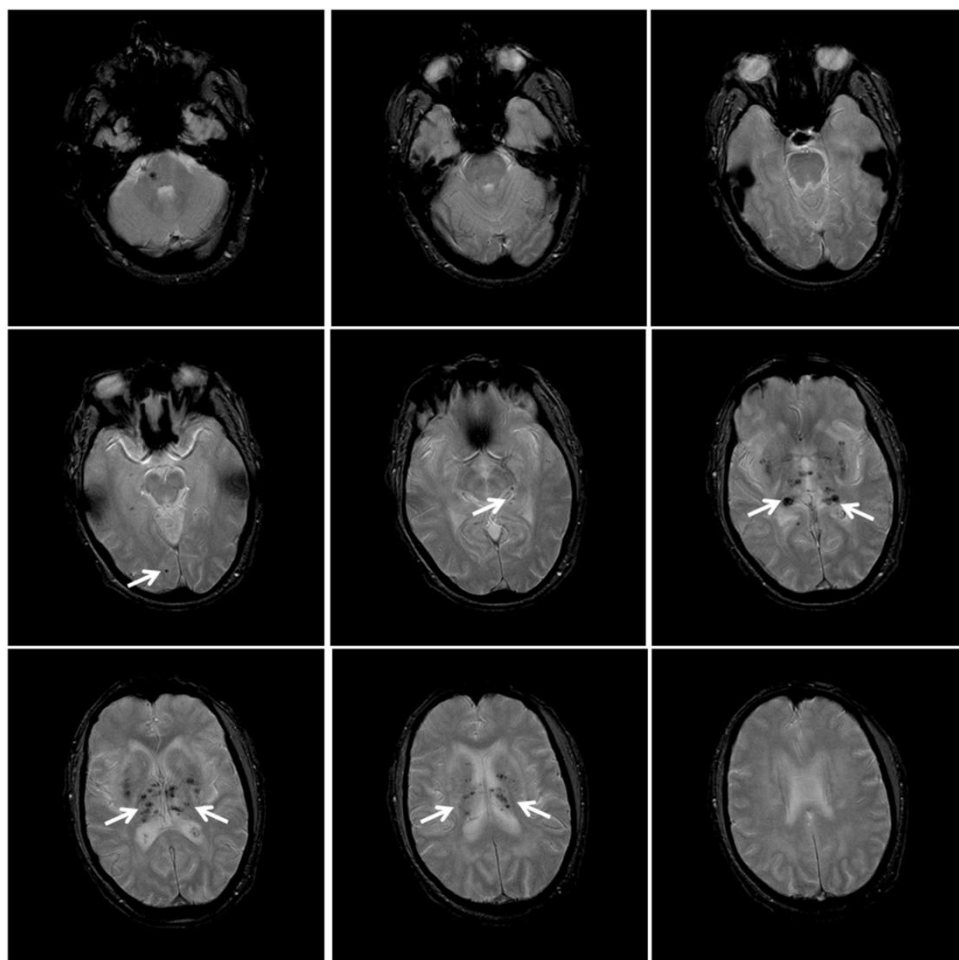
T2-weighted MRI axial images from the brain of a patient diagnosed with CADASIL. White arrows indicate microangiopathies. Images kindly provided by the Neurology Department of the Hospital La Princesa.
